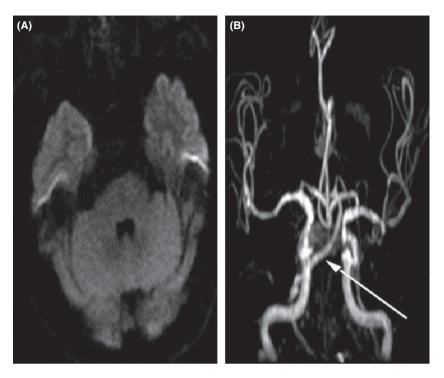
(A) No lesions on DWI after thrombolysis, DWI, axial. (B) The basilar artery presented with moderate stenosis on MRA after thrombolysis (the arrow), MRA, coronal.
